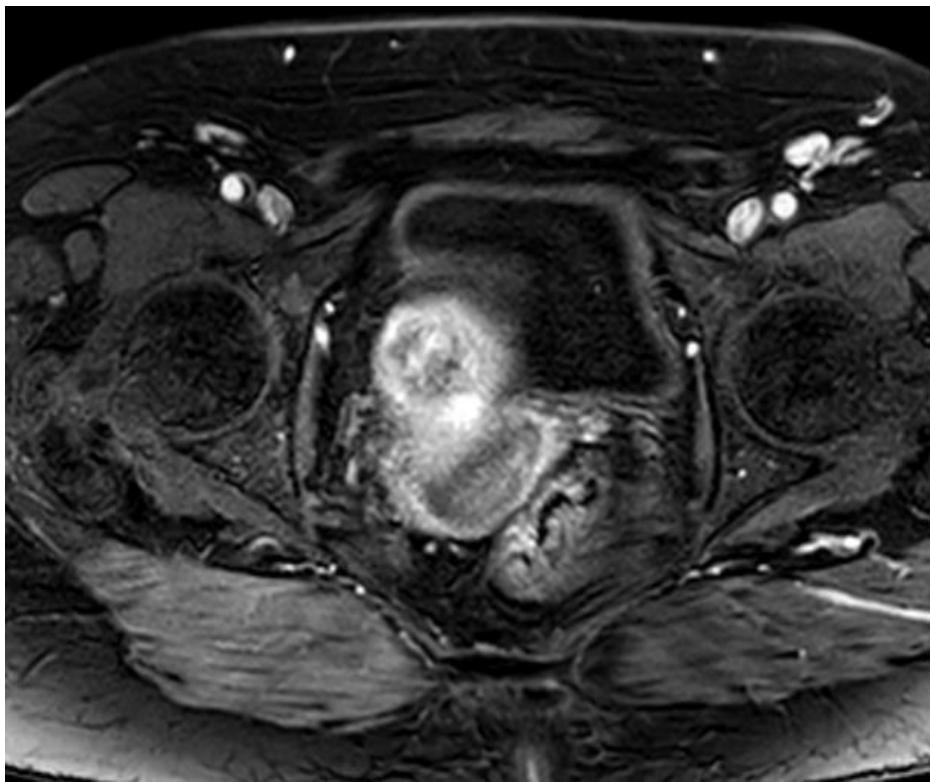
Axial contrast-enhanced MRI sequence showing heterogeneous enhancement of the lesion (Case 1).
